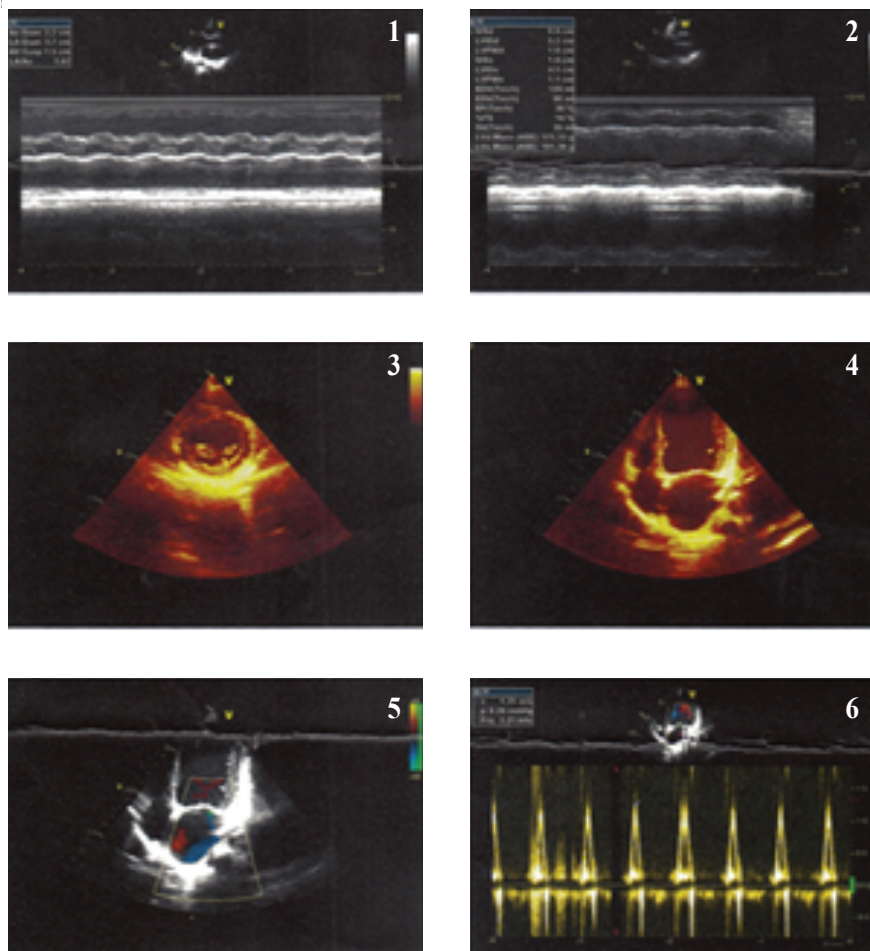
2D echocardiographic image of same female patient shows dilatation of left ventricle, Left ventricular EDD (End Diastolic Diameter) = 5.2 cm and ESD (End Systolic Diameter) = 4.5 cm, EDV (End diastolic volume) in Teich. method=139 ml, ESV(End Systolic Volume) in Teich. method=90 ml, EF (Ejection Fraction)= 30% and image 6 shows compensatory tachycardia, all the parameters diagnosed her as Dilated Cardiomyopathy patient.
